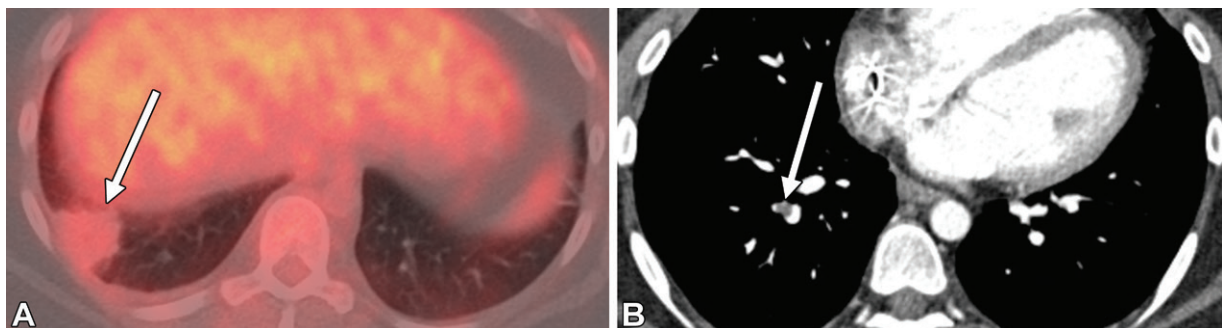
Peripheral consolidation concerning for possible pulmonary infarction in a 29-year-old woman with lymphoma who presented for restaging FDG PET/CT following recent completion of chemotherapy. (A) Transaxial fused FDG PET/CT image shows a peripheral wedge-shaped consolidation (arrow) with mild FDG avidity in the right lower lobe. The differential diagnosis included pulmonary infarction, resolving pneumonia, and less likely, tumor. (B) Subsequent contrast-enhanced CT image findings confirmed the presence of PE (arrow) in a segmental right lower lobe pulmonary artery.
